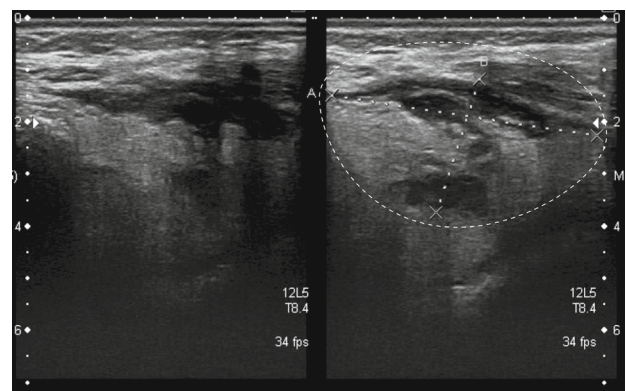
Ultrasound: Heterogeneous image adjacent to the splenic flexure of the colon, measuring 2.5 cm × 5 cm.
